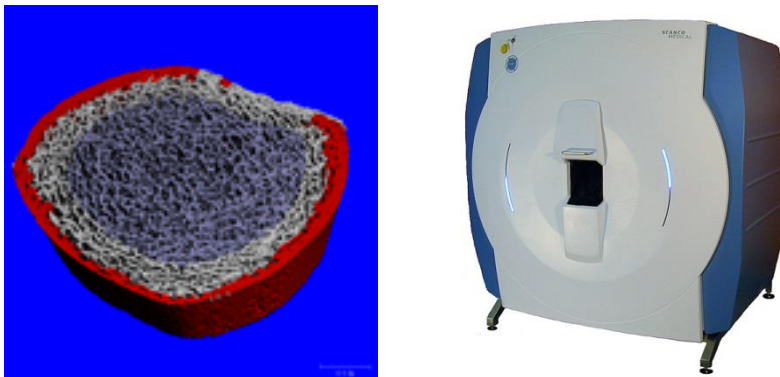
Image of tibia segmentation, as assessed with high-resolution peripheral quantitative computed tomography (XtremaCT, Scanco Medical AG, Brüttisellen, Switzerland).
